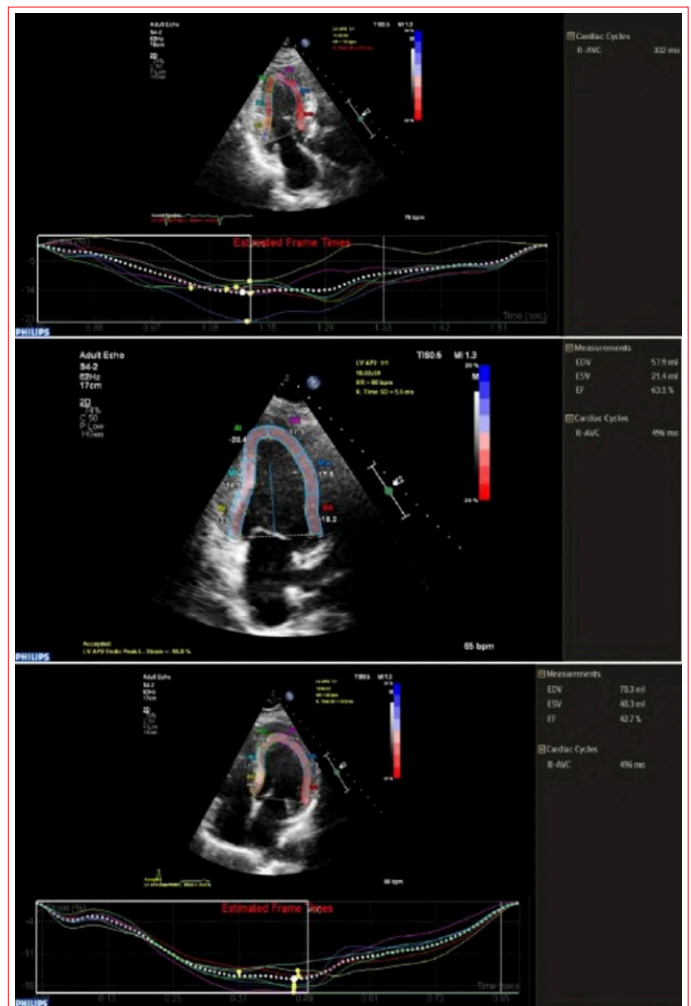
Multilayer GLS image acquisition. Left ventricular multilayer strain imaging: apical 2-chamber and apical 3-chamber, apical 4-chamber images (A: UPPER; 3-chamber image, B: MIDDLE; 2-chamber image, BOTTOM; 4-chamber image).
